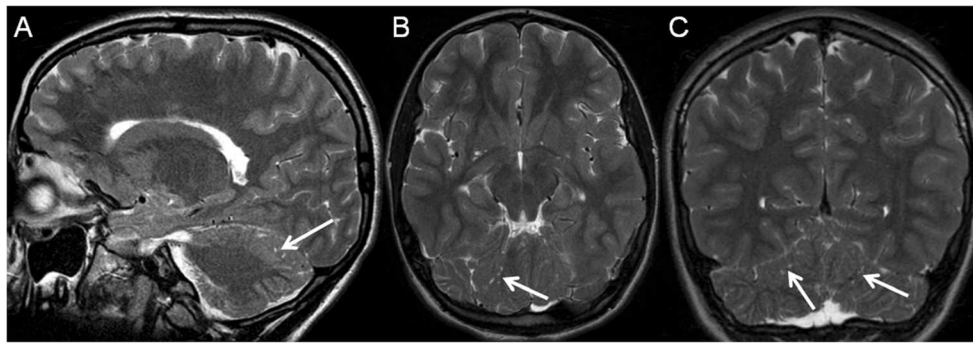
A 11-year-old girl with non-progressive cerebellar ataxia, ocular motor apraxia, and normal cognitive functions. Midsagittal (a), axial (b), and coronal (c) T2-weighted images show multiple small cortical-subcortical cysts in the upper and posterior parts of the cerebellum
